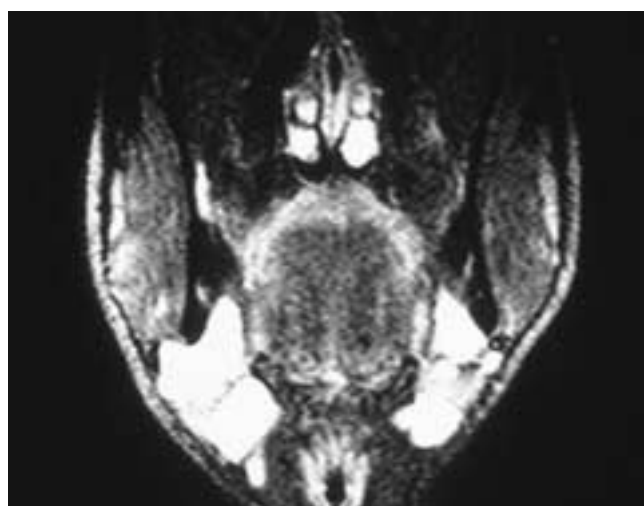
Coronal T2-weighted MR image shows bilateral cystic high signal intensity masses extending from the floor of the mouth into the submandibular triangles. This patient had bilateral ranulas.
